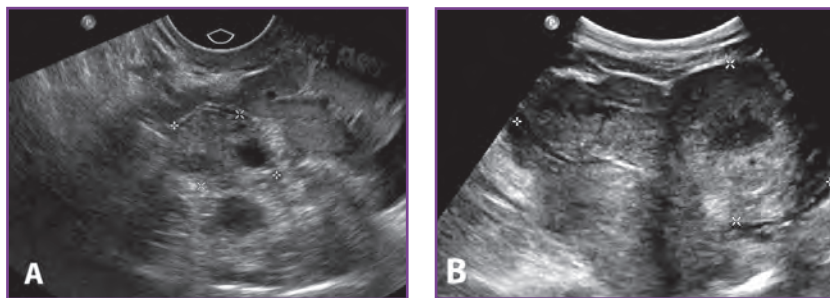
Pelvic ultrasonographic images of a female adolescent who presented with right-sided abdominal pain. A, A normal-appearing left ovary and a large, lobulated mass in the right pelvis with no normal ovary was identified. B, The mass is predominantly solid, with a few small cystic components that are concerning for malignancy.
